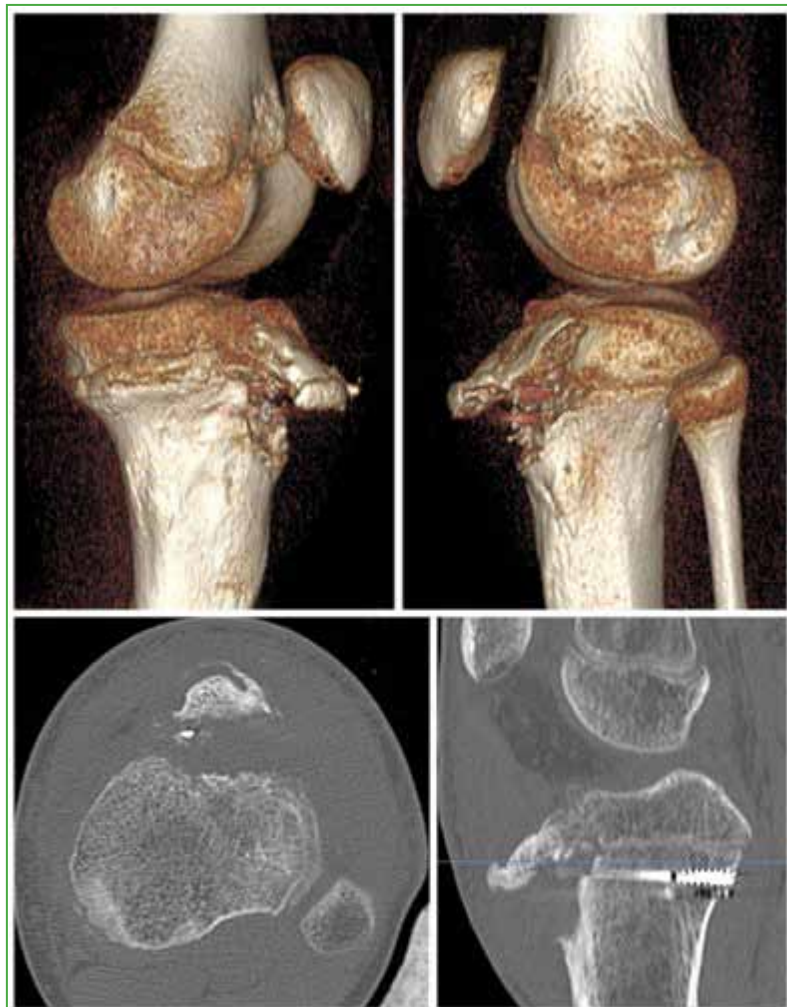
Computed tomography of the knee. The refracture with previous consolidated line is observed.
